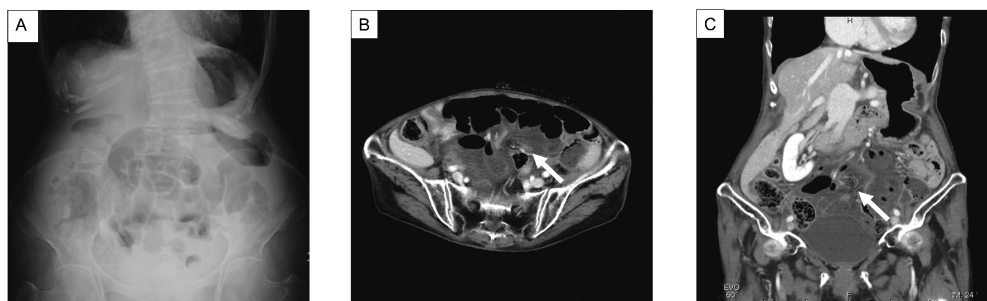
(A) Abdominal radiograph showing multiple distended small bowel loops with air-fluid levels. (B, C) Axial and coronal contrast-enhanced CT images (B: axial, C: coronal). CT images showed that a part of small intestine was poorly enhanced with torsion (arrows).
